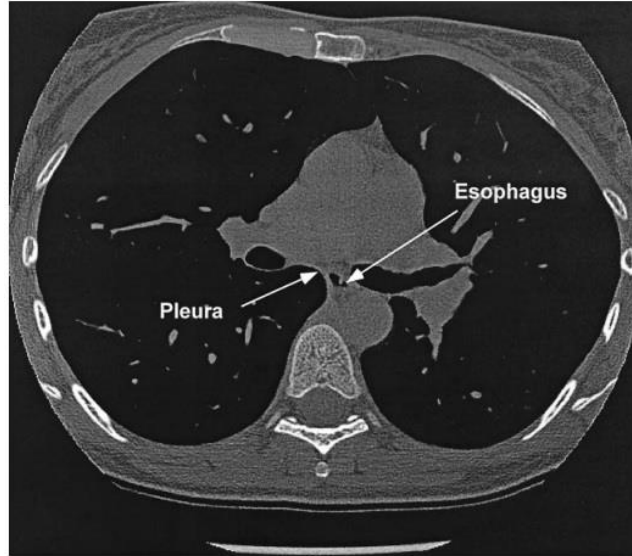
Computed tomography of the chest, showing that the esophagus is adjacent to the pleural space in the mid thorax⁵⁸.
